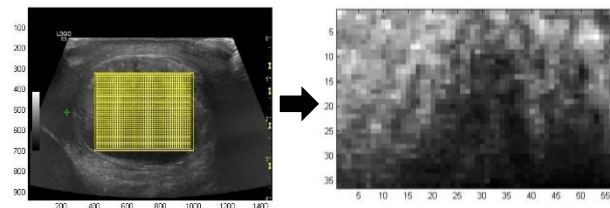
Converting ultrasound image to binary map
